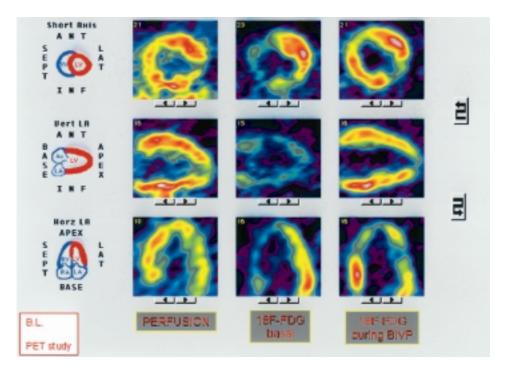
Patient with a biventricular pacemaker: a clear defect in ¹⁸F-fluorodeoxyglucose (FDG) uptake in the septum, not associated with a defect in perfusion, is present before implant; a homogeneous distribution of FDG uptake in the myocardial walls during biventricular pacing may be observed. Left panels: ¹³N-ammonia; middle panels: ¹⁸F-FDG before implant; right panels: ¹⁸F-FDG during biventricular pacing; top panels: midventricular short-axis slices, middle panels: midventricular vertical long-axis slices, bottom panels: midventricular horizontal long-axis slices.
